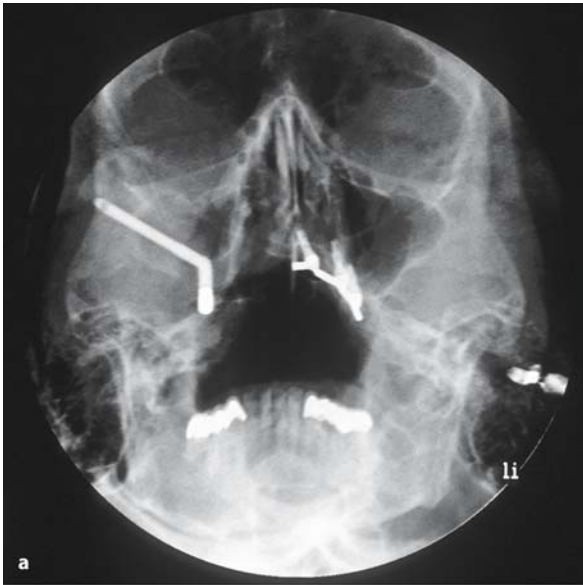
Zygomatic implant and three dental implants for treatment with an obturator prosthesis. The radiograph (a) is a paranasal sinus projection taken after the insertion of an obturator prosthesis following a partial resection of the mandible for a malignant tumor. b Abutments. c Inserted prosthesis
